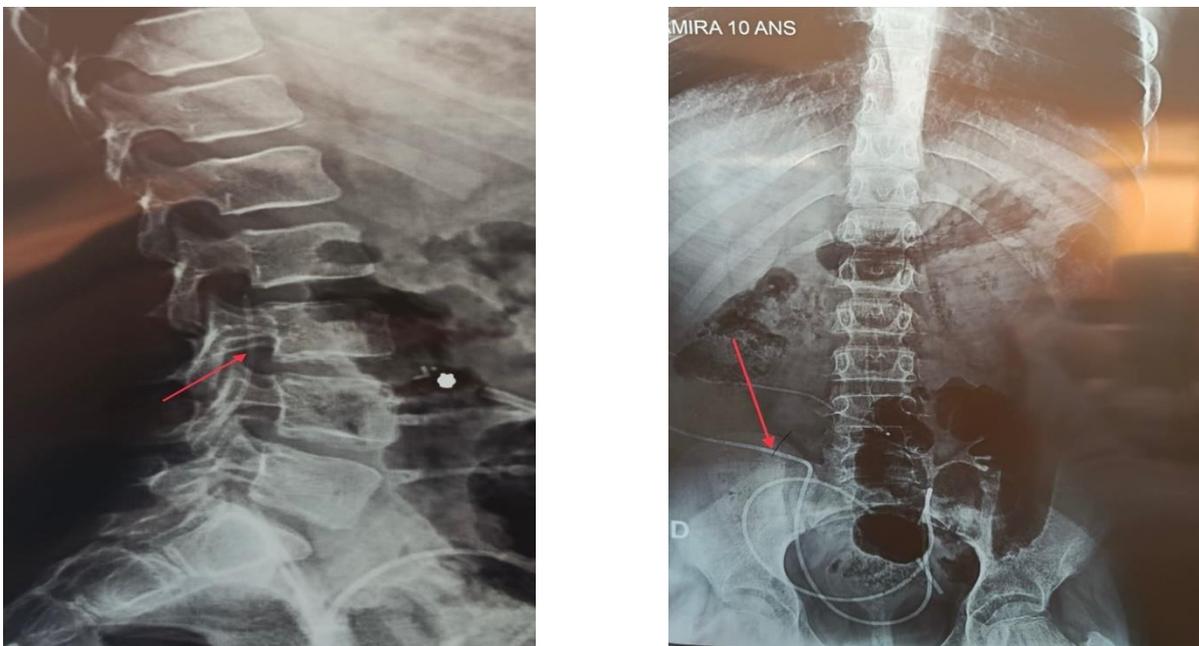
Postoperatively, Anteroposterior and Lateral Radiographs Demonstrate A Catheter in an Intraperitoneal and Intraforaminal Position.
